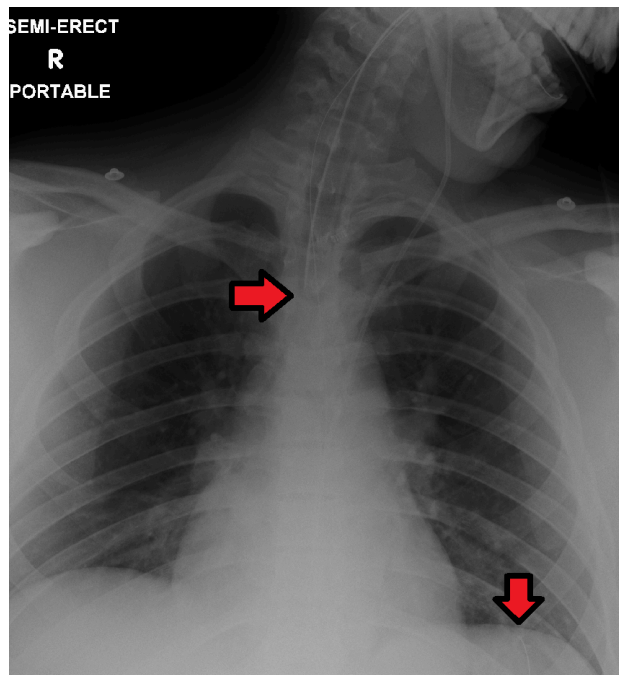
Placement Verification by X-Ray
